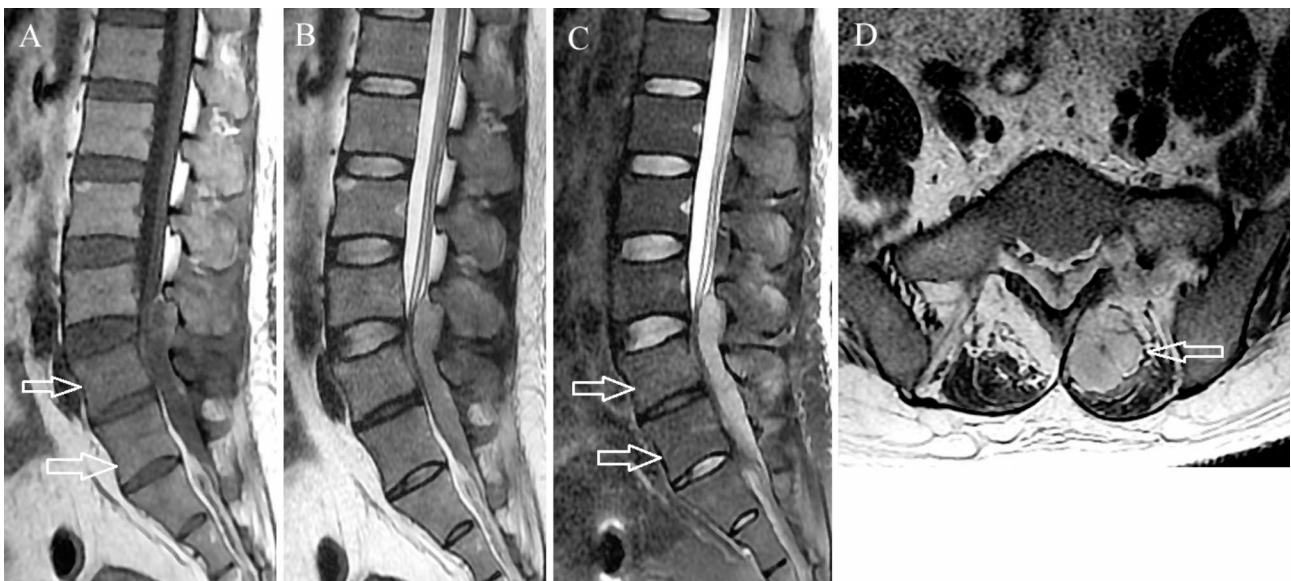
Abscess stage primary L3-5 spinal epidural abscess in a 41-year-old man. (A) On axial T1-weighted imaging, the abscess is hypointense and dorsal to thecal sac. Mild vertebral body edema is seen in the L4 and L5 vertebral bodies (arrows). (B) The abscess appears hyperintense on sagittal T2-weighted imaging. (C) Sagittal short tau inversion recovery imaging shows mild hyperintensity within the L4 and L5 vertebral bodies (arrows). (D) Axial T2-weighted imaging shows an abscess in the posterior paraspinal muscles (arrow)
